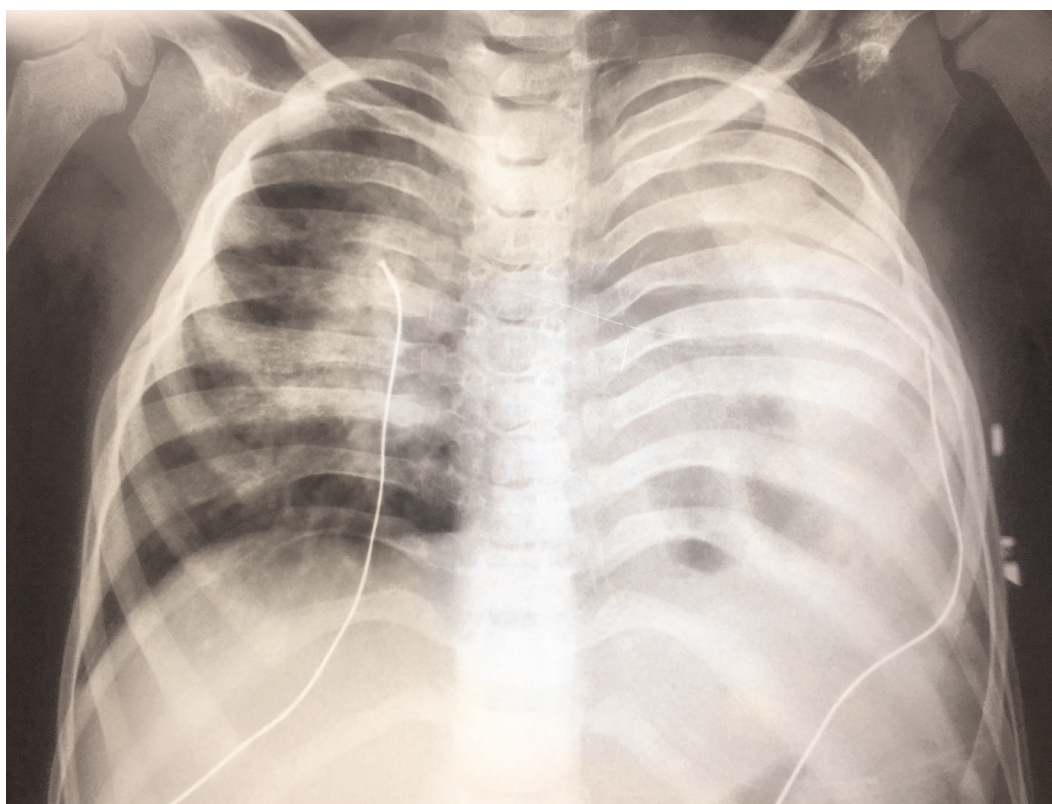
Chest x-ray at the time of hospital admission
